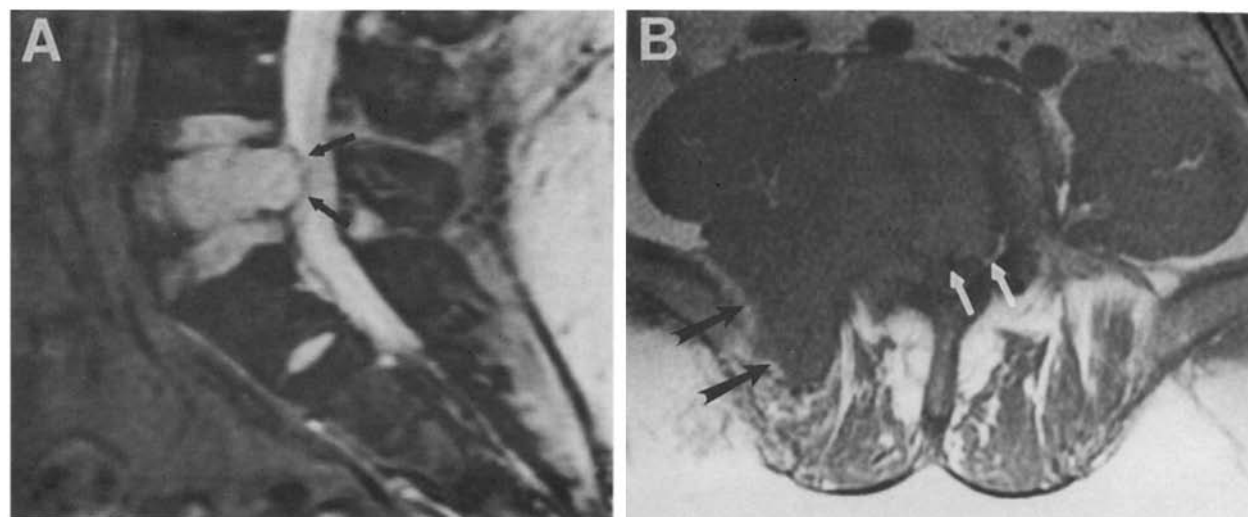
(A) GRASS sagittal MR image (250/20; 20-degree flip angle) shows hyperintense signal intensity in the L-5 vertebra, which is compressed. Note extension of tumor into the spinal canal (arrows). (B) Axial T1-weighted MR image (600/20) at the level of L-5 shows tumor in the spinal canal (white arrows) and in the right paraspinal region (black arrows).
